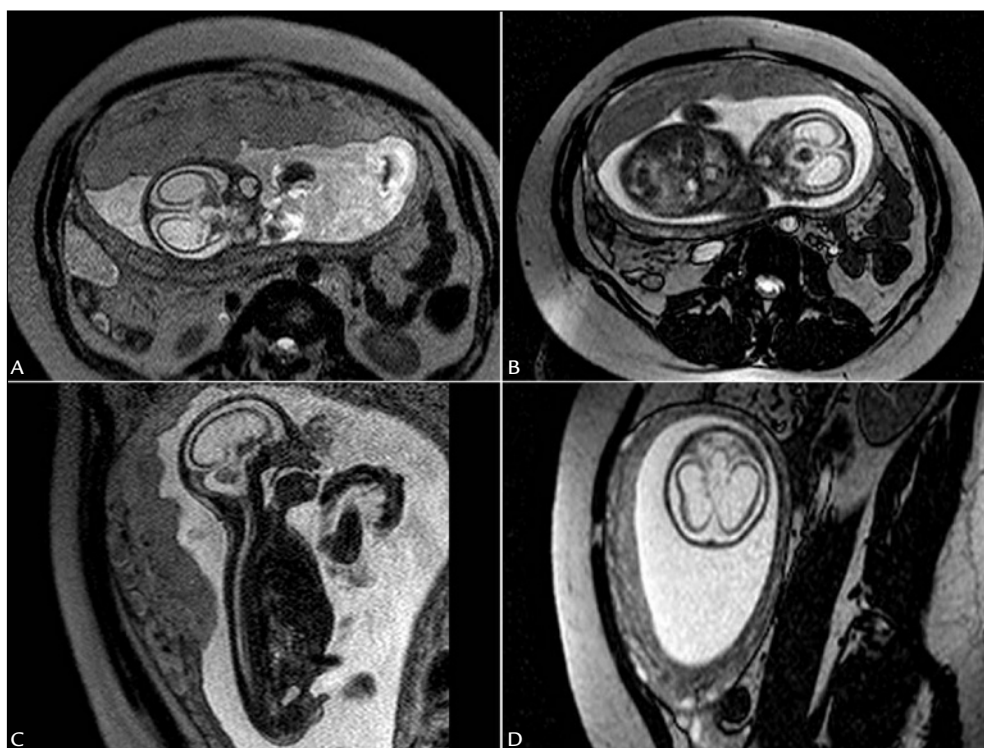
Fetal magnetic resonance imaging, T2-weighted sequence demonstrating pronounced lateral ventriculomegaly on both sides associated with significant volumetric reduction and diffuse thinning of the cerebral parenchyma.
